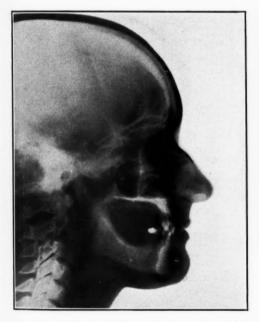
Prosthodontic profile roentgenogram taken before all opposing teeth were extracted.
